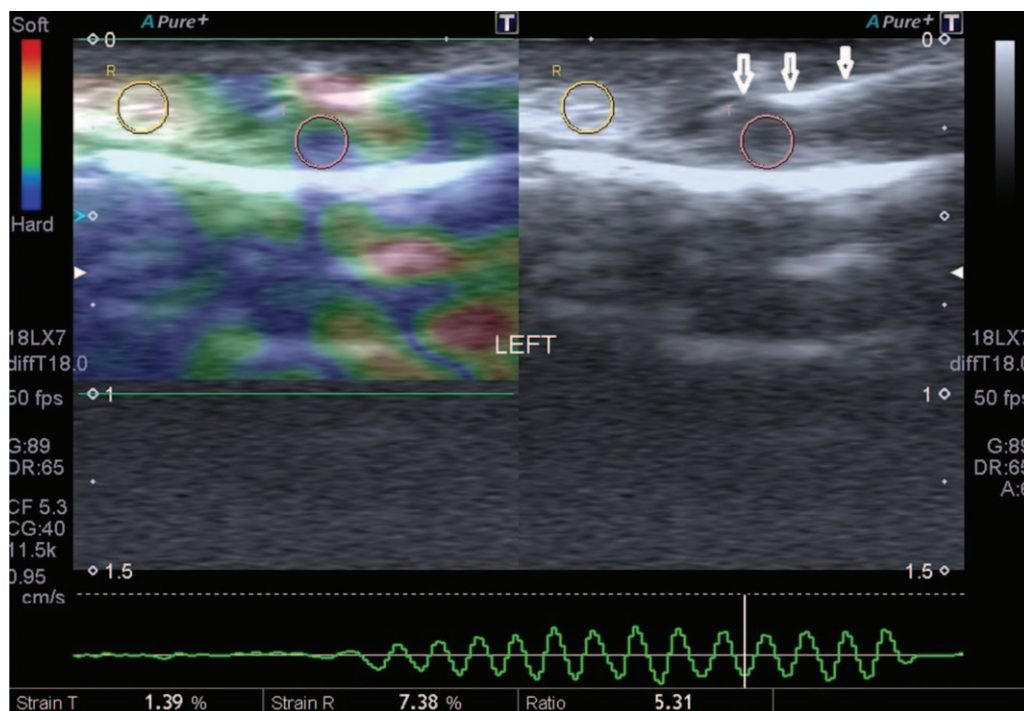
Demonstration of ultrasonographic elastogram measurement (arrows: nail).
